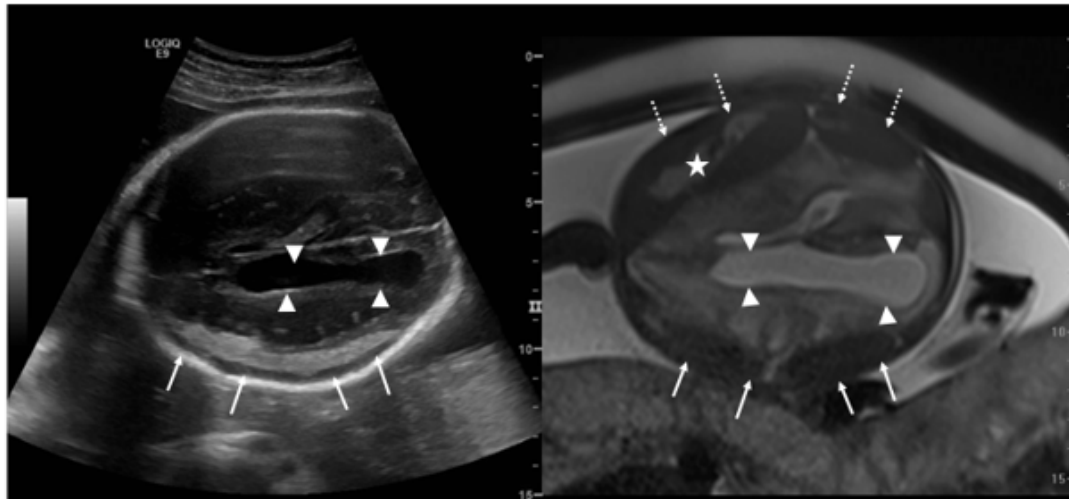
Fusion image of a fetus at a gestational age of 32 weeks. On ultrasound, the bilateral subdural bleeding is seen most clearly in the deeper hemisphere with a large hyperechoic sickle-shaped structure (small white arrows) compressing the hemisphere with enlargement of the lateral ventricle, (white arrowhead). The superficial half of the skull is not easily seen on ultrasound. On MR, the same findings are seen in the deeper half of the skull. In the superficial half, the subdural hematoma is even larger (dashed arrows) and contains a large clot (white star), again compressing the brain parenchyma. Cubicle is seen with a unilateral cleft lip (white arrow).
